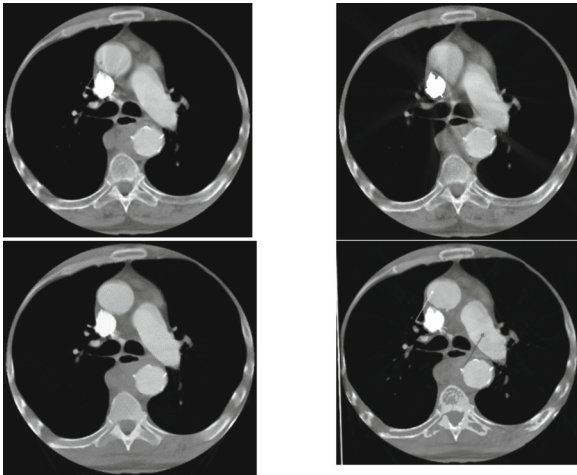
Patient CT slice: Original (left up), LIMAR (right up), ISMAR (left down) and NMAR (right down)
